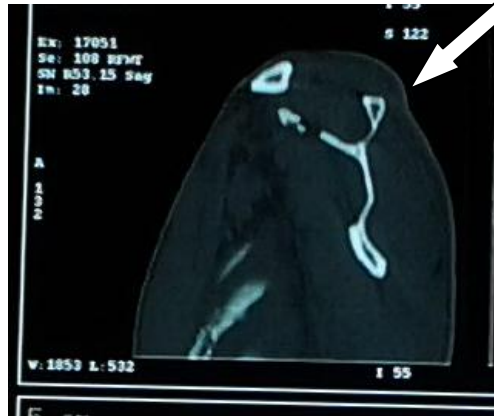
Saggital section of the CT scan showing the fracture of the upper border of scapula- marked with an arrow
